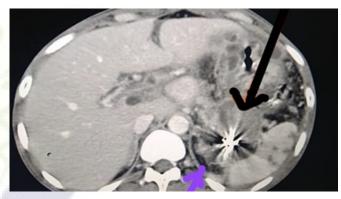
Follow up CT Scan demonstrating coils within the distal splenic artery with complete embolization and no active leak.
